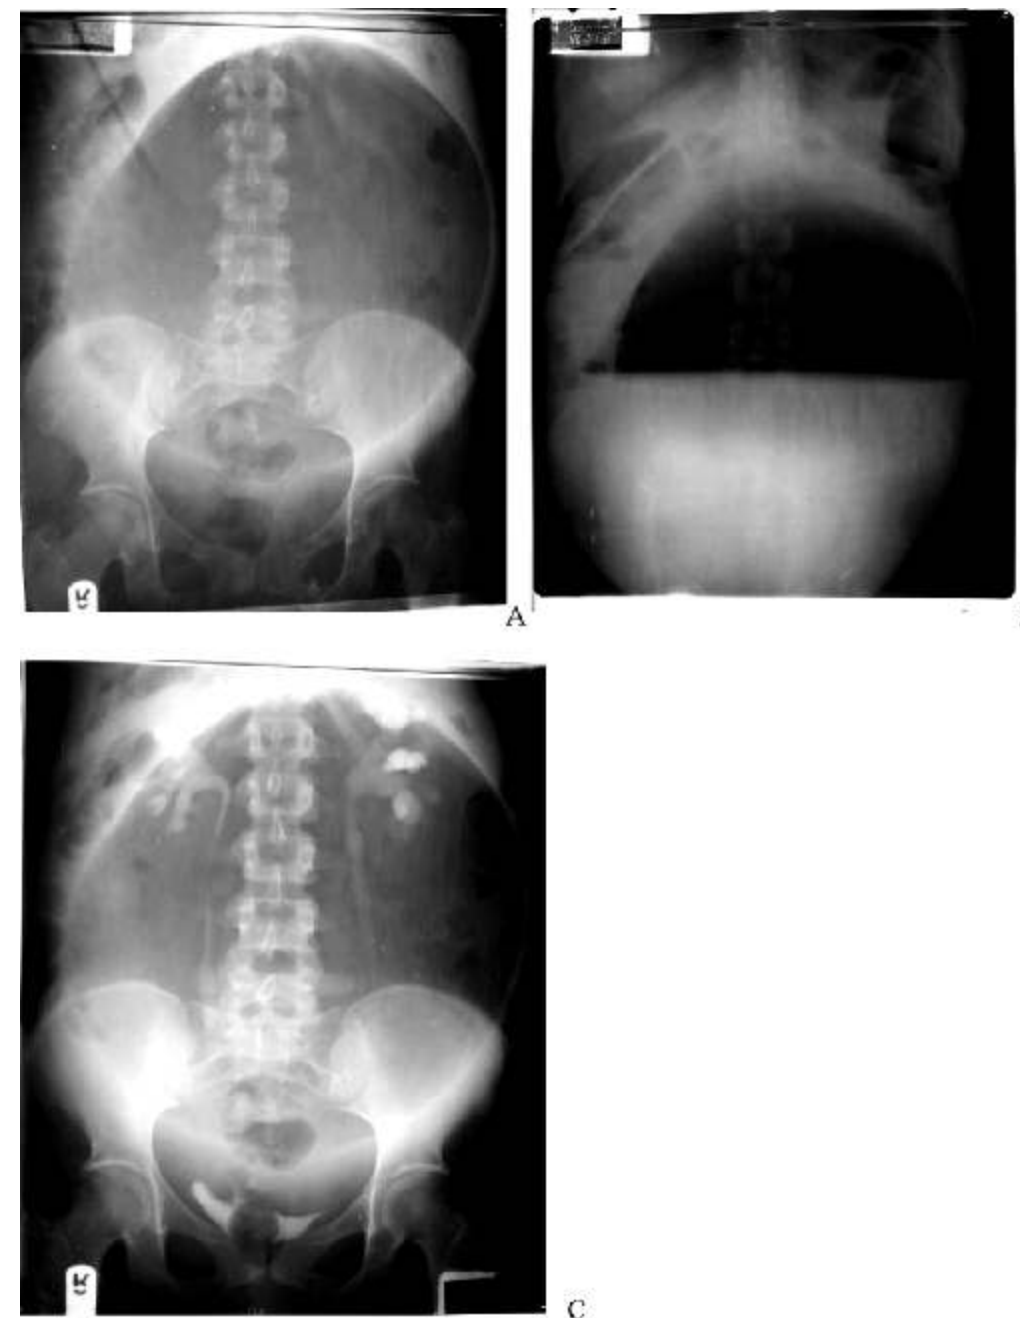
Abdominal radiographs showing giant intra-abdominal abscess. (A) Supine radiograph showing well-marginated rounded homogeneous extraluminal lucency; (B) Erect radiograph demonstrating giant air-fluid level and (C) Delayed intravenous urogram of the same patient showing bilateral hydronephrosis. Note also the previously demonstrated giant homogeneous lucency due to the abscess.
